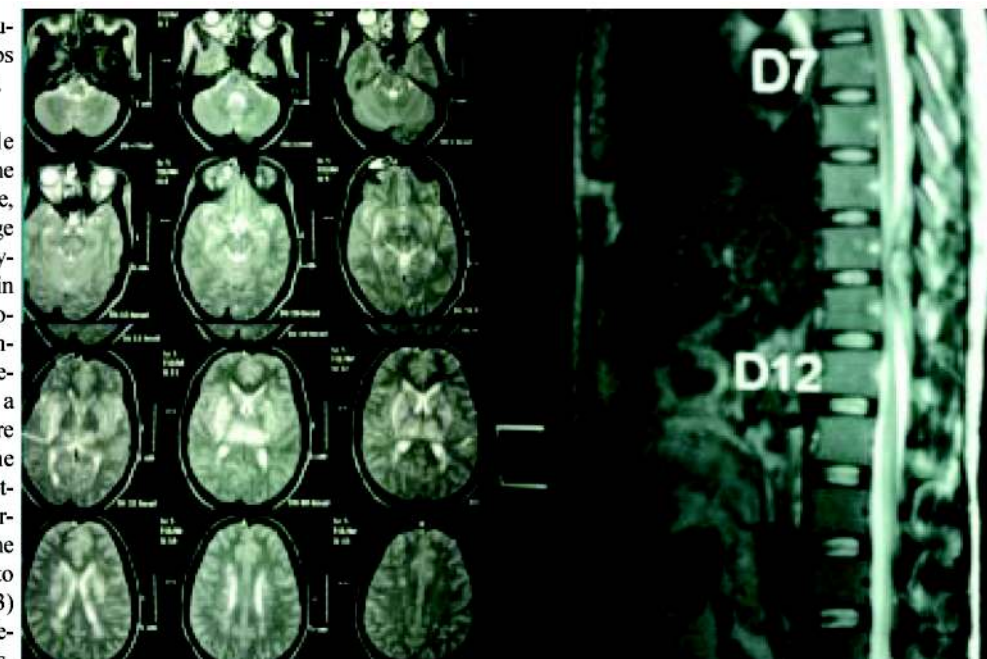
MRI brain and dorsal spine at the onset of illness
